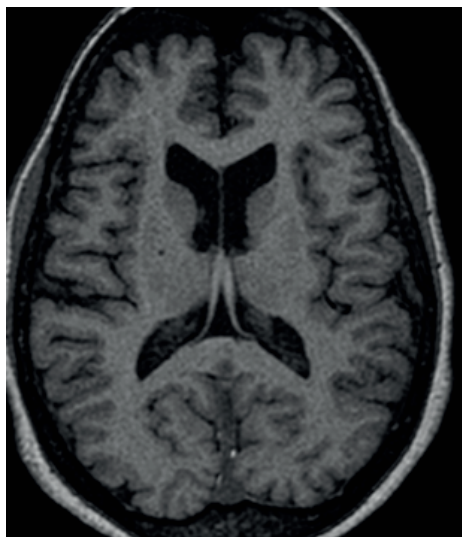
Cranial MRI in axial T1-weighted section displaying the ventricular system with preserved dimensions, and the cerebral parenchyma maintaining morphology and signal intensity without alterations.
